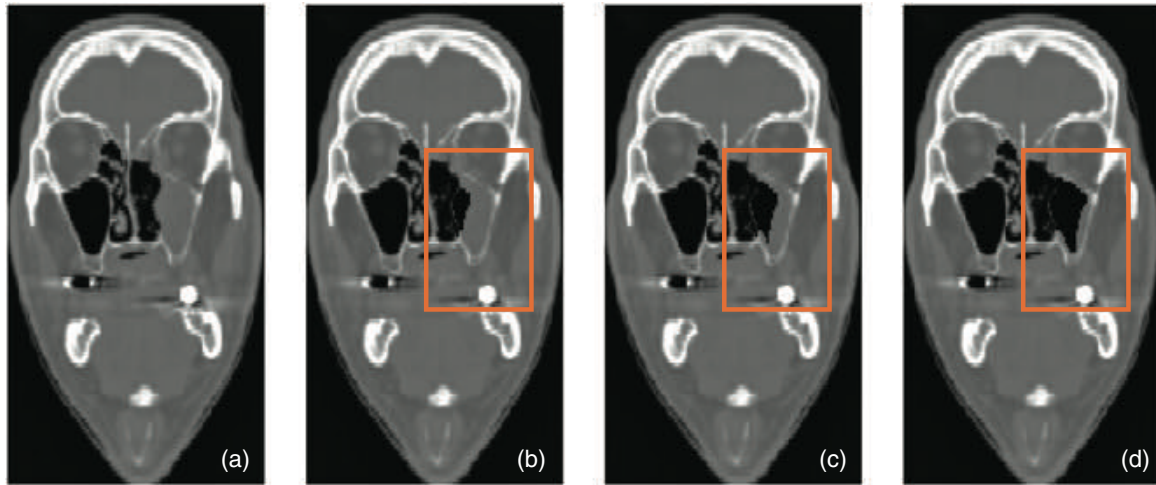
Examples of artificially created CTs with different sizes of cavity tissue volume reductions: 0 mL (the planning CT, (a)), 3.8 mL (b), 7.3 mL (c), and 13.1 mL (d). The region of interest containing the left sinonasal cavity is highlighted with an orange rectangle
